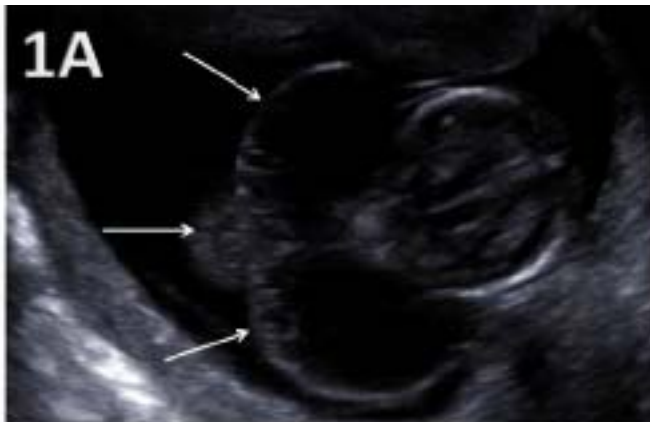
Ultrasound examination and macroscopic features of the affected fetus A: White arrows indicating septated cystic hygroma behind the neck of the fetus
